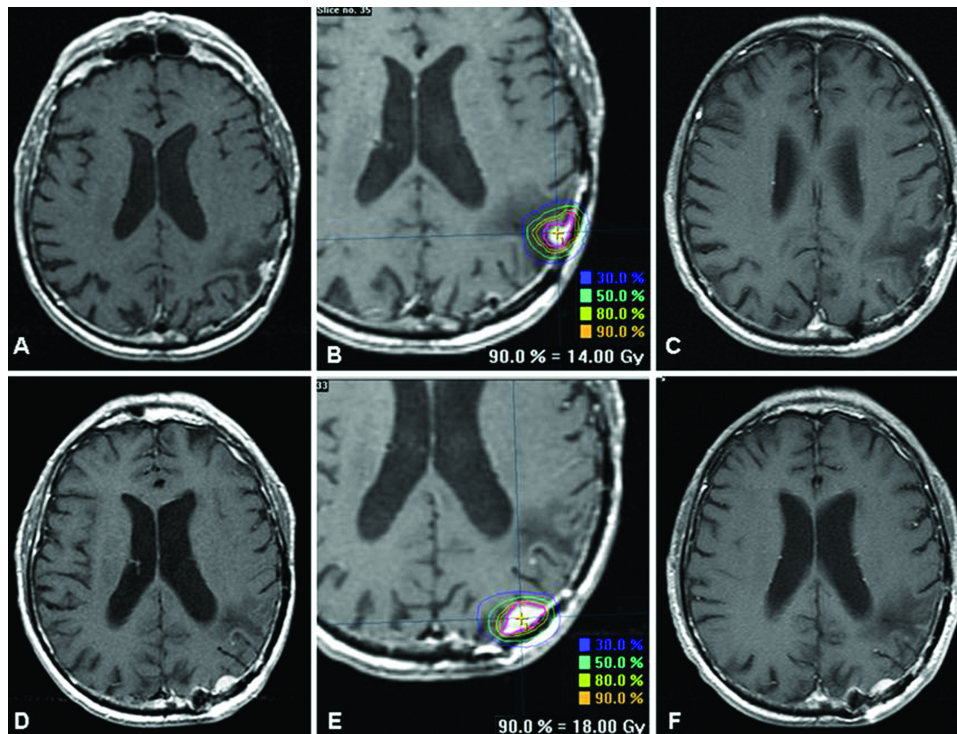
Axial MR images obtained in a 78-year-old man who had undergone surgery for a Grade II meningioma 5 years earlier and developed a recurrent lesion (A and B), which was treated using SRS. This lesion was under control 18 months after treatment (C), although 6 months after the first SRS session another lesion was found to have developed inside the original tumor resection cavity (D). A second session of SRS was required for this new lesion (E), which was under control after 1 year of follow up (F).
